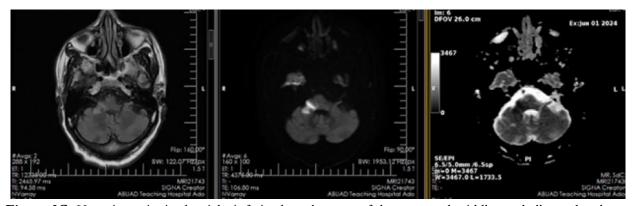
Hyperintensity in the right mid-lateral aspect of the pons on FLAIR and DWI, with diffusion restriction on ADC
